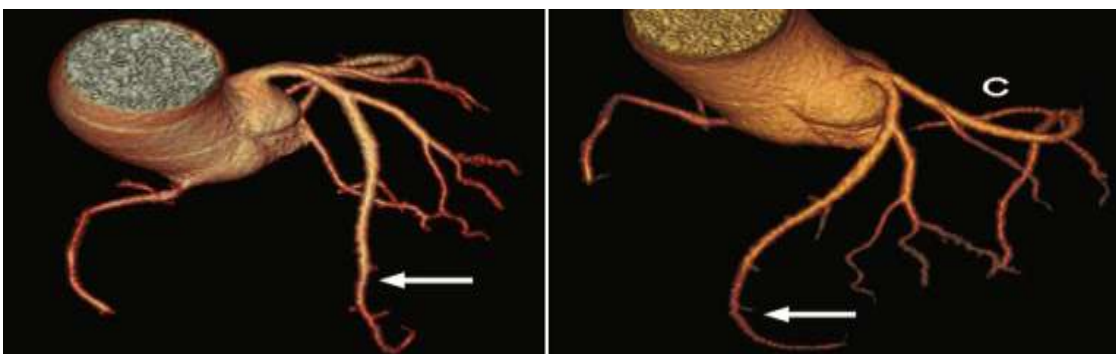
A contrast-enhanced CT angiogram demonstrating long segments of the LAD (arrow). Images such as seen here can be created which are much more similar to a conventional coronary angiogram, if desired.
